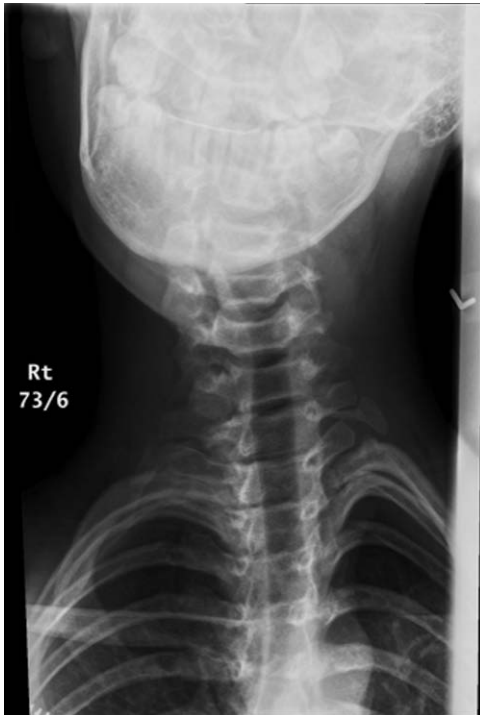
X-ray showing the subject’s head position. With no neurological signs or peripheral nerve complaints, the patient retained full flexion and right-sided cervical rotation. Neck extension was limited to 20 degrees, and left cervical rotation did not go beyond midline.
